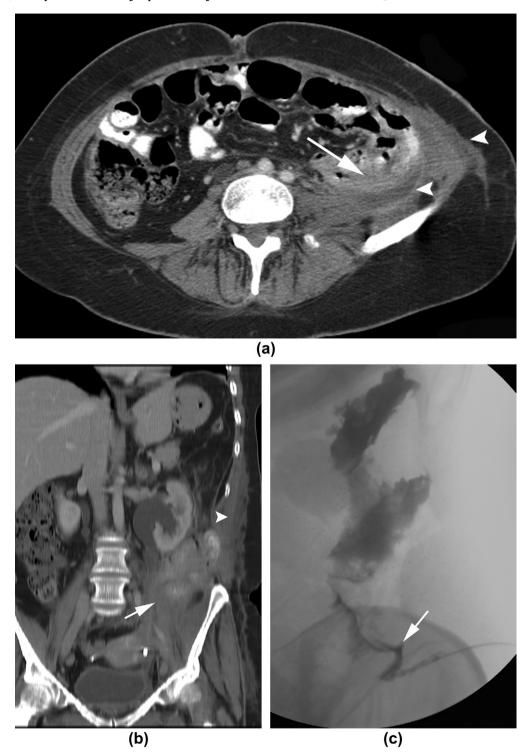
A 33-year-old woman with pyrexia and abdominal pain. (a) Axial CT shows multiple abscesses in the abdominal wall (arrowheads) adjacent to the descending colon (arrow). (b) Coronal CT image shows an infiltrative mass (arrow) ascending from the pelvis involving bowel loops with flank abscess (arrowhead). Note the radiodense IUD in the uterus and hydronephrosis due to ureteric involvement. (c) A sonogram shows the irregular appearance of the descending colon with a fistulation (arrow).
